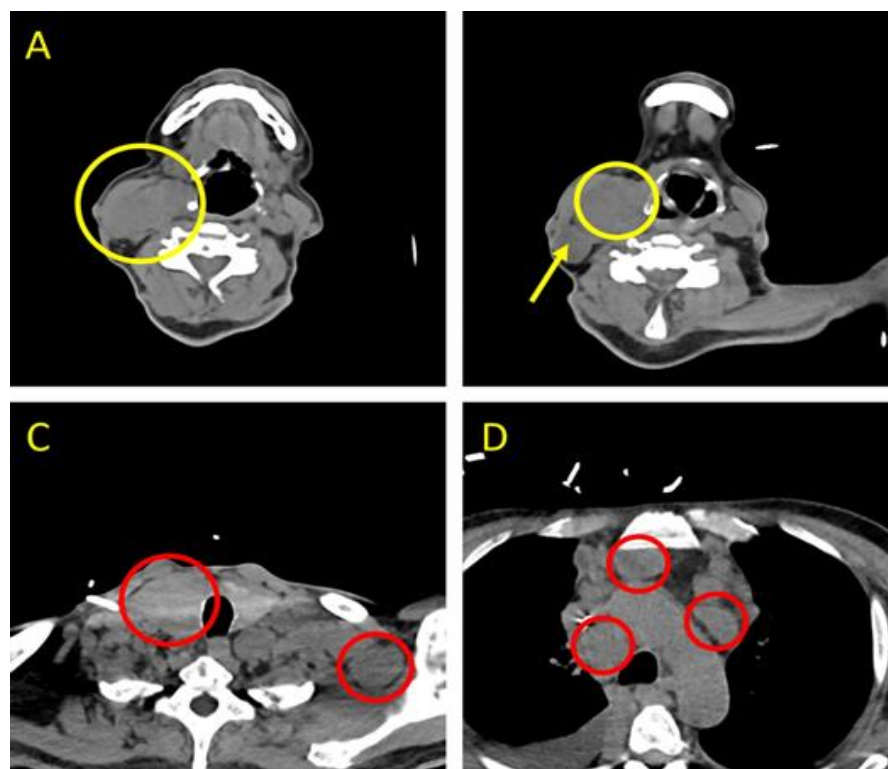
Computed Tomography (CT) of the neck. (a-b) Mass of the right thyroid measuring 4.3 cm x 3.7 cm x 5.1 cm (yellow circles) and cervical lymphadenopathy (yellow arrow). (c-d) Extensive mediastinal lymphadenopathy (red circles).
